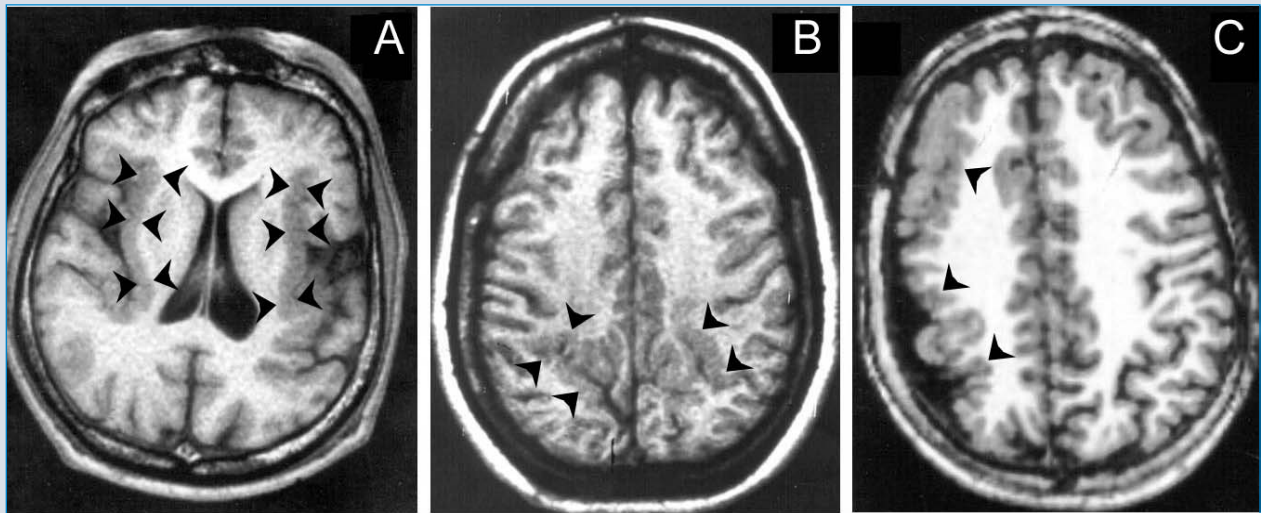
(A) Brain MRI; T1weighted axial section. Bilateral perisylvian polymicrogyria. Sylvian fissures are open and the perisylvian cortex is thickened and irregular (black arrows). Young man with Lennox–Gastaut syndrome. (B) Brain MRI; T1weighted axial section. Bilateral parasagittal polymicrogyria. Irregular thickening and infolding of the cortex at the mesial parieto-occipital junction (black arrows). Young girl with intractable partial epilepsy. (C) Brain MRI; T1 weighted axial section. Unilateral polymicrogyria. The right hemisphere is smaller than the left and the subarachnoid space overlying the right hemisphere is enlarged (black arrows). The cortex on the right is irregular, with areas of thickening. Eight-year-old boy with left hemiparesis, moderate mental retardation, atypical absences and partial motor seizures.
